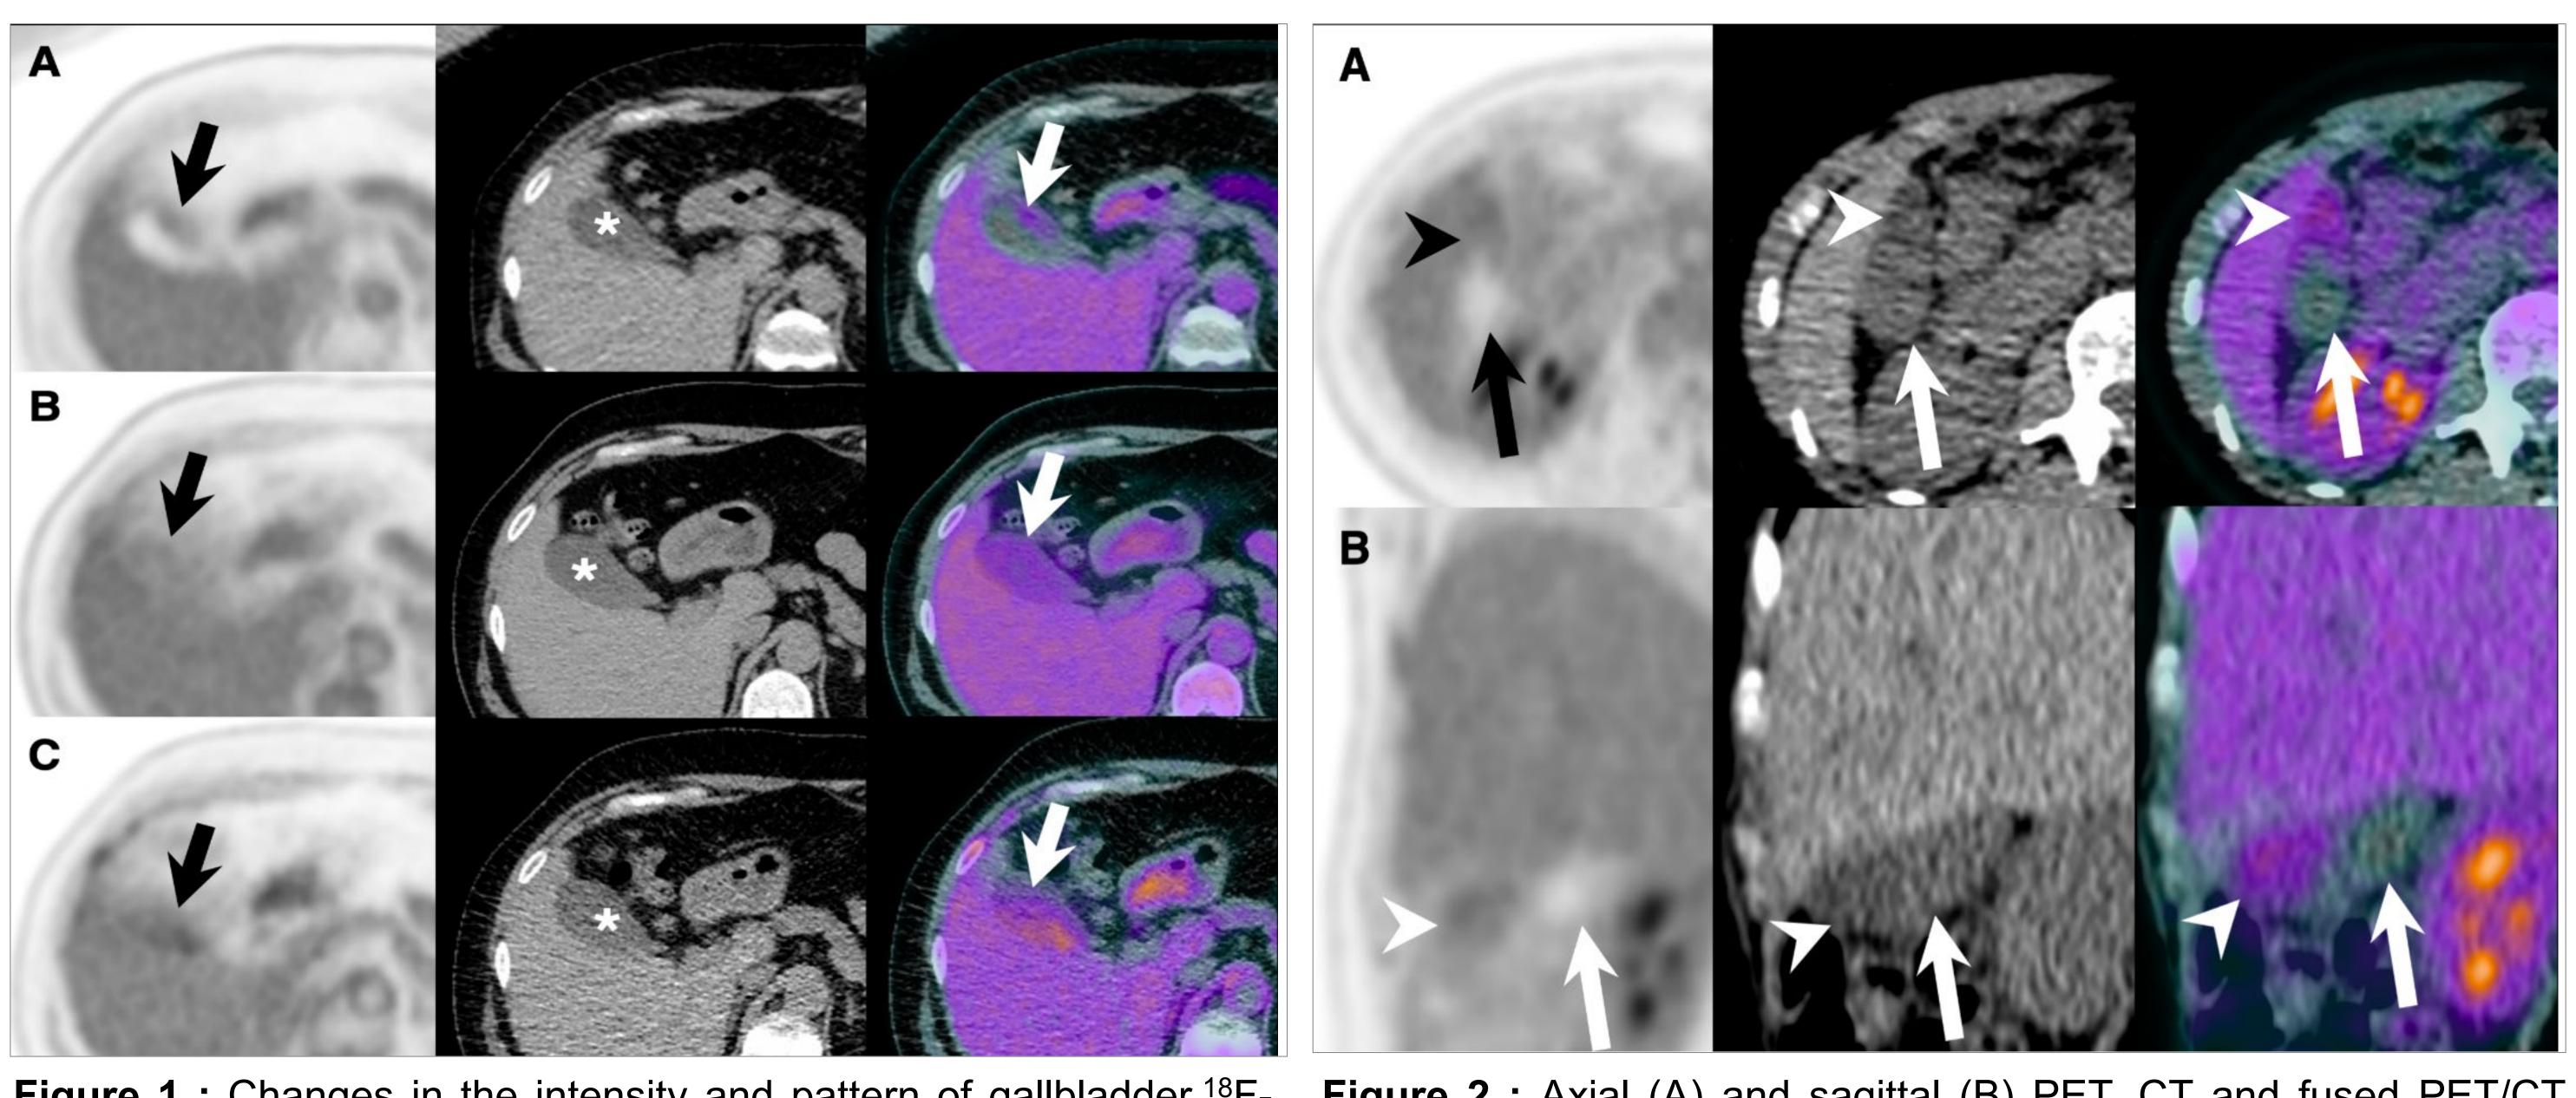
Changes in the intensity and pattern of gallbladder <sup>18</sup>F- Figure 2 : Axial (A) and sagittal (B) PET, CT and fused PET/CT FDG uptake on serial total-body PET/CT acquisitions. Axial PET, CT images of a 61 y/o healthy female participant, scanned at 90and fused images acquired after i.v. injection of 389 MBq in a 53 y/o minute post-injection of 334 MBq of <sup>18</sup>F-FDG. Images show healthy female participant. (A) images at 40-minute timepoint distribution of <sup>18</sup>F-FDG uptake in the gallbladder: one portion shows showing wall activity, equal to the liver background; (B) images at uptake with lower attenuation on the corresponding CT 90-minute timepoint showing luminal uptake, equal to the liver (arrowhead), while the other portion shows no uptake and higher uptake; and (C) images acquired at 180-minute post-injection attenuation on the corresponding CT (arrow). These findings showing increased luminal uptake, higher than that of the liver suggest the presence of different luminal content. background. The gallbladder lumen is indicated by an asterisk (\*) in the CT images.
